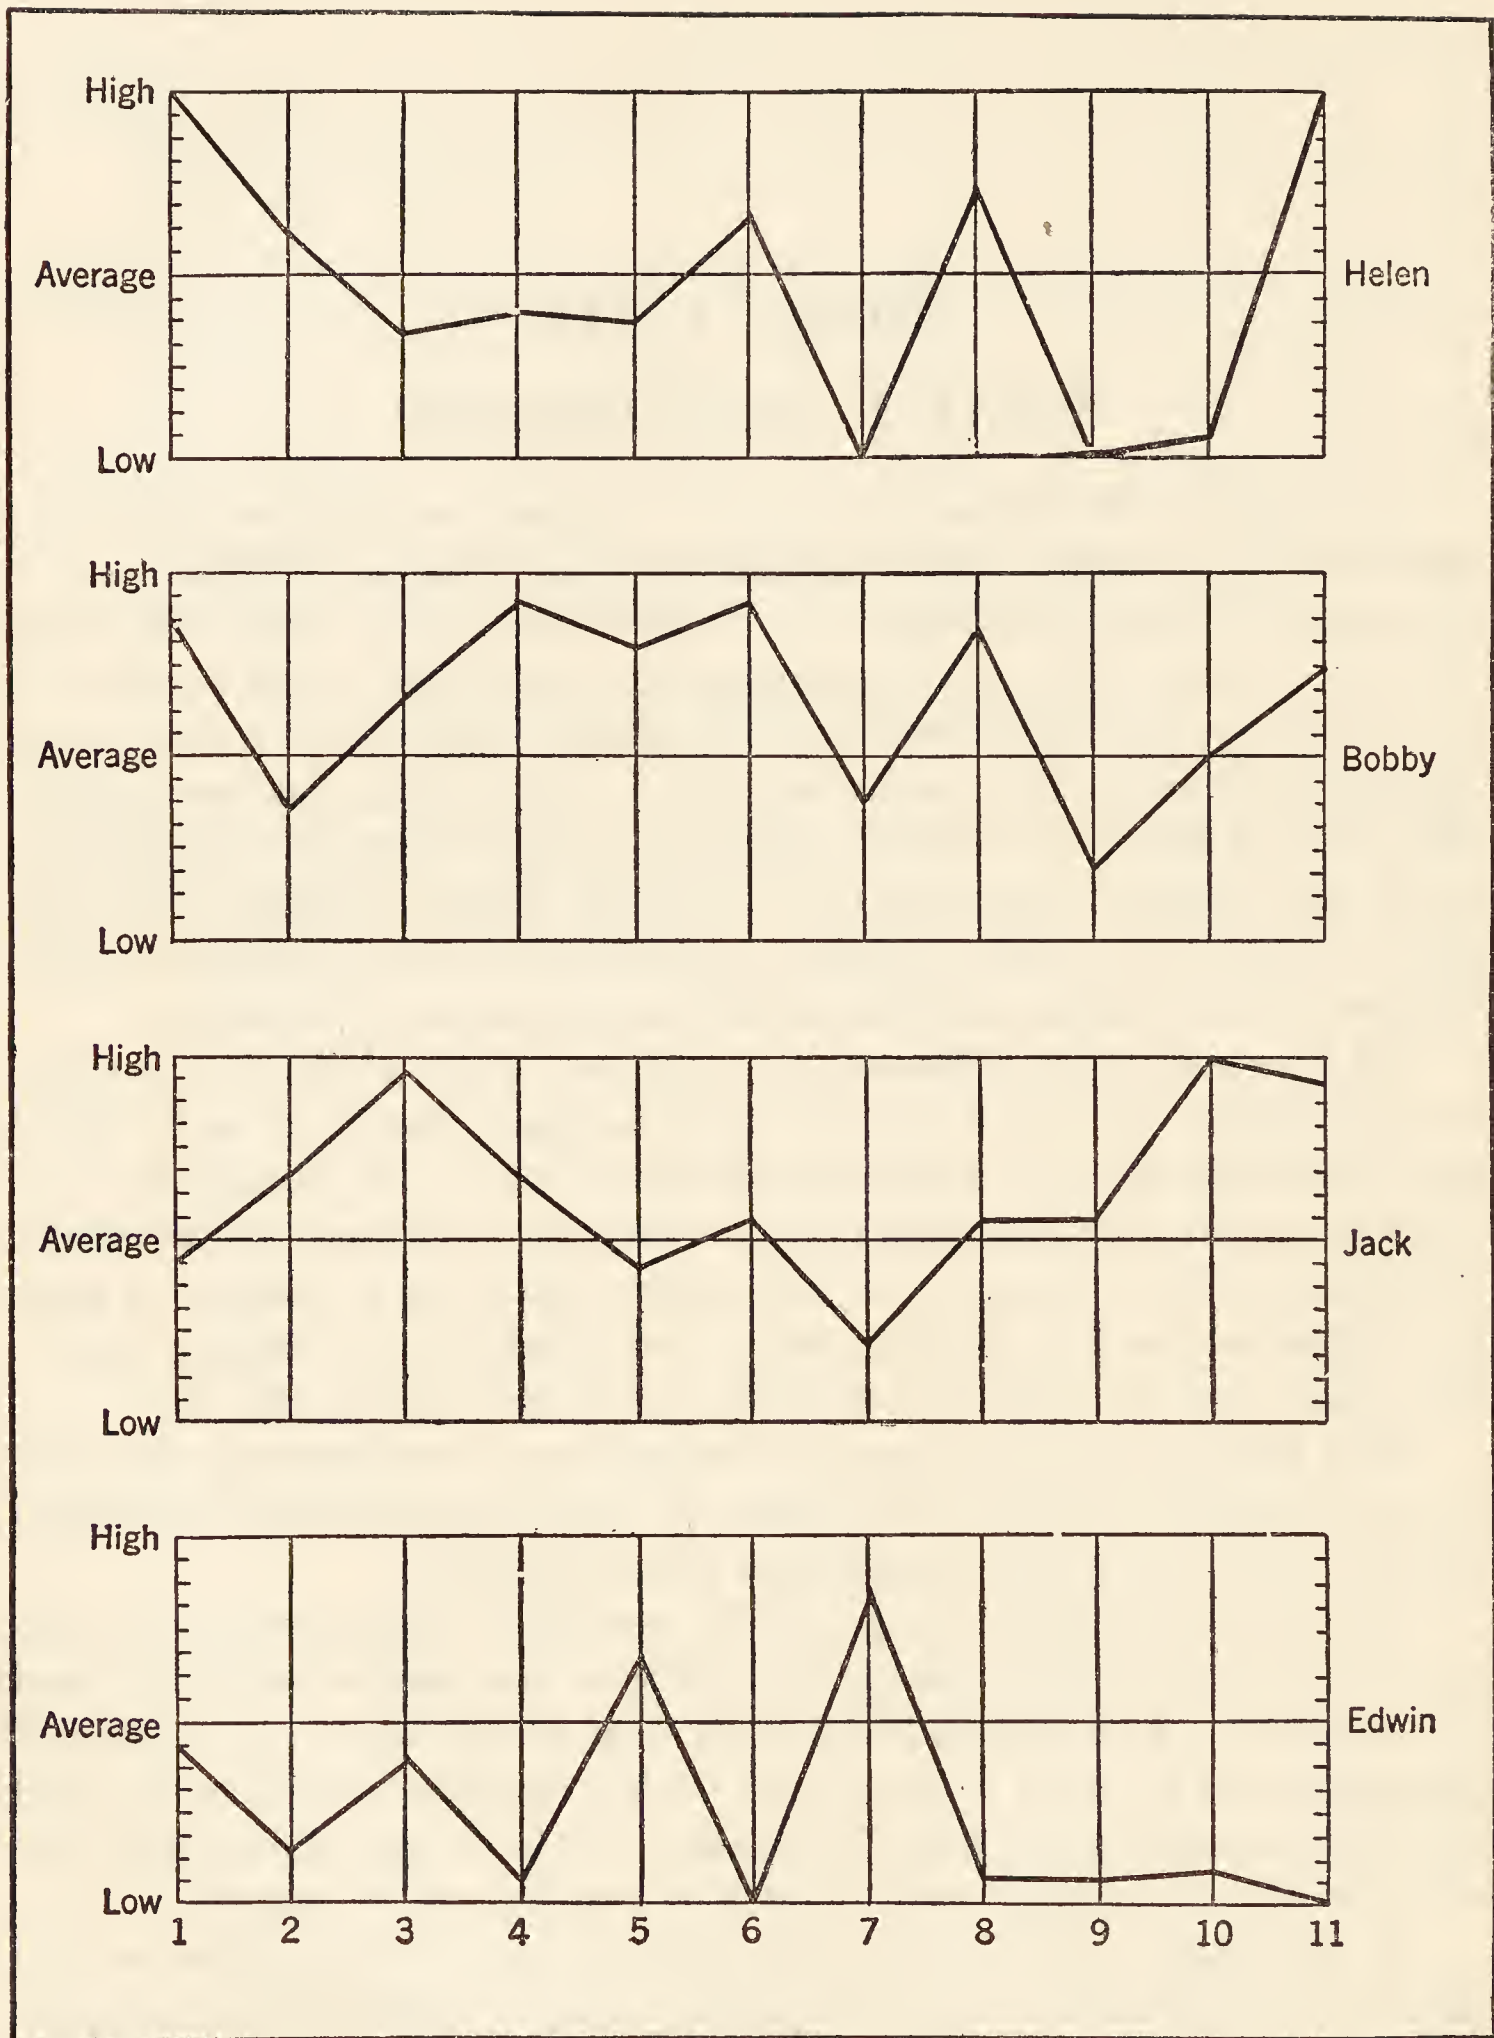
RATINGS OF PRESCHOOL CHILDREN ON ASPECTS OF SOCIAL ADJUSTMENT.
